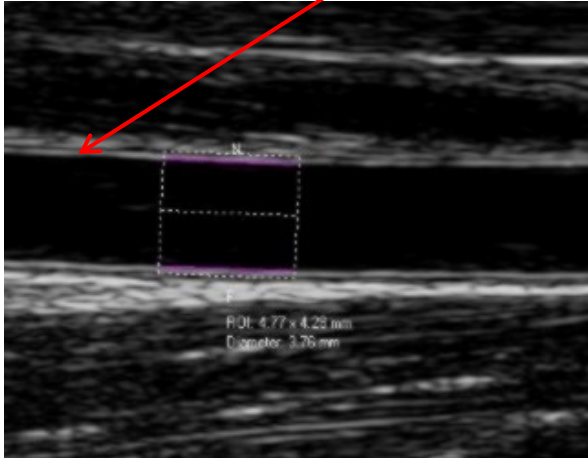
Longitudinal view of the artery with B-mode ultrasound, with automated edge-detection software being used (111).
